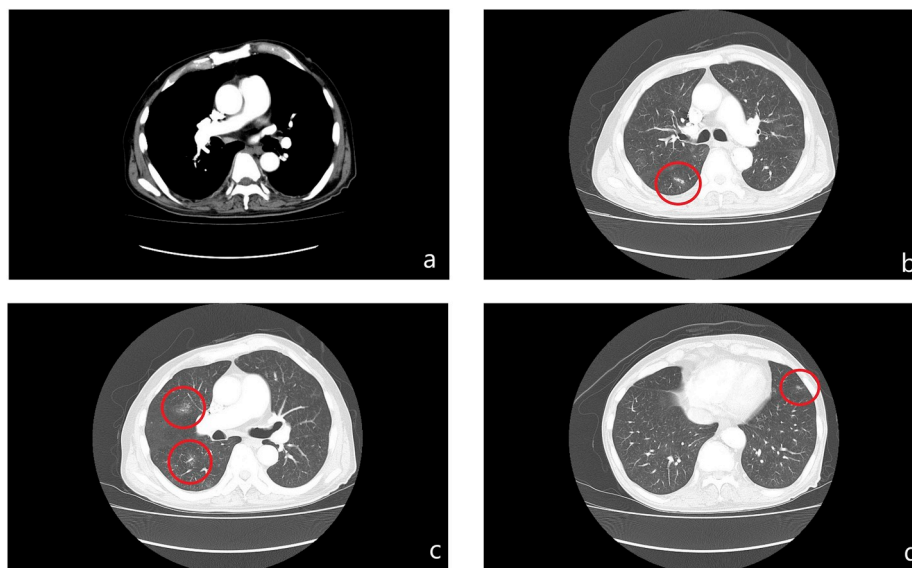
(a) Contrast-enhanced computed tomography (CT) shows no arterial defects. (b–d) CT in the lung window setting shows diffuse ground-glass opacities (GGOs).
